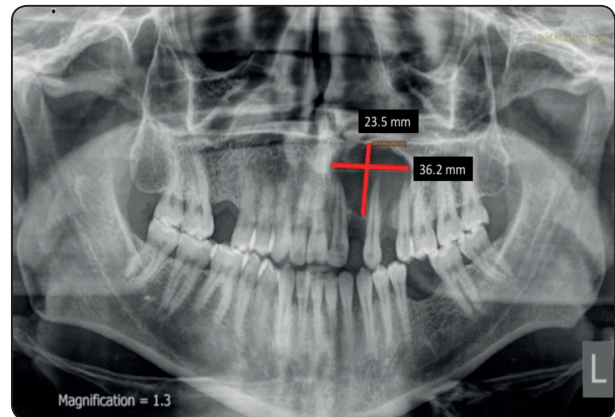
Preoperative Orthopantomogram with the measurements of the cystic cavity.
